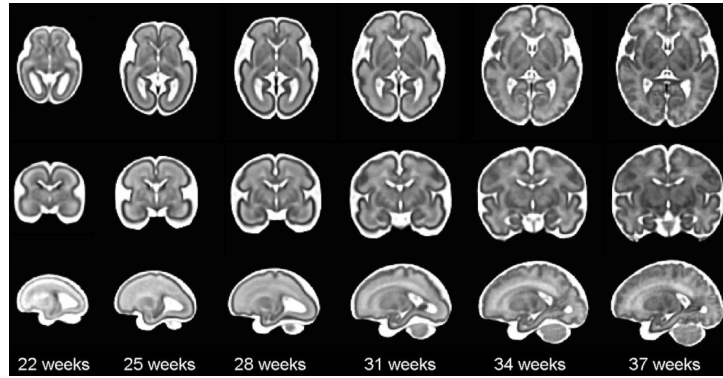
MRI of fetal brain at different gestational age in coronal, axial and sagittal view
